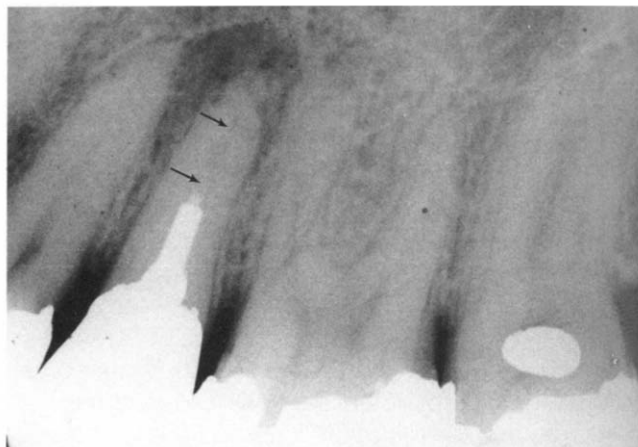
Case 2, preoperative radiograph. Note the unfilled canal space apical to the post (arrows) and the large periradicular radiolucency.
